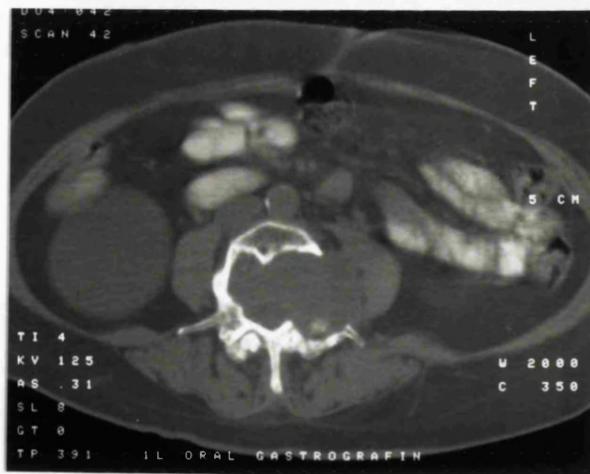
CT scan showing expanding lesion in L4.
